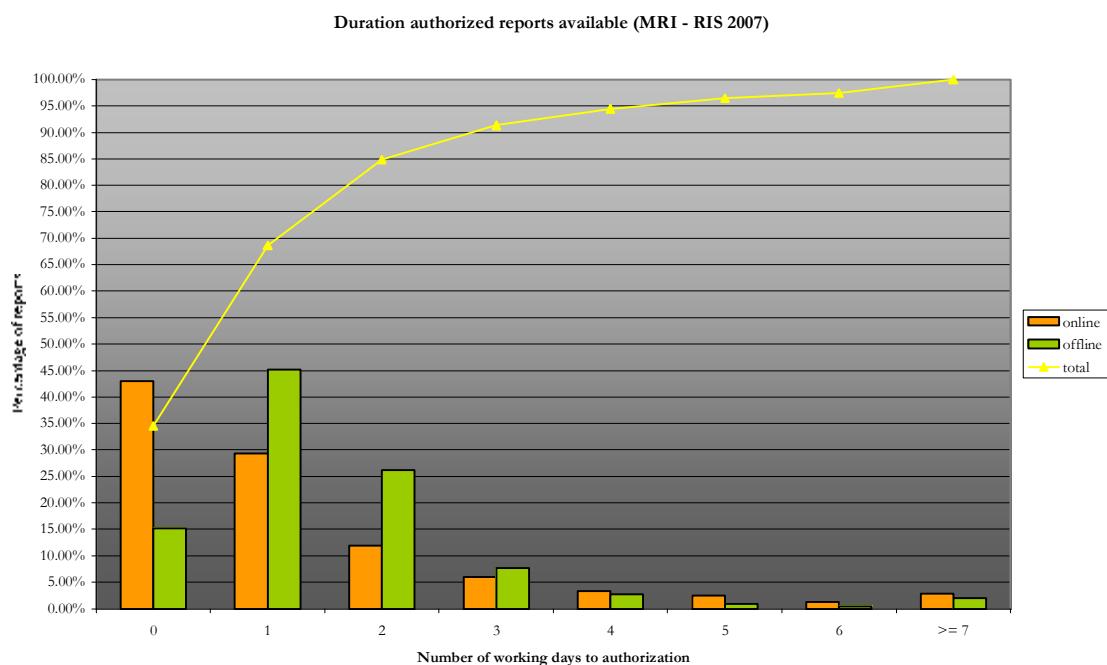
Throughput time radiology report MRI-scanner: online versus offline (RIS 2007)
